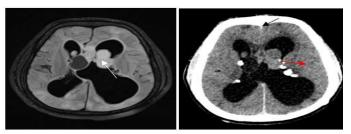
MRI brain FLAIR image and Non contrast CT brain showing well-circumscribed solid cystic mass at the foramen of Monro with extension into bilateral lateral ventricles (white arrow). Calcified subependymal nodule(red arrow)
